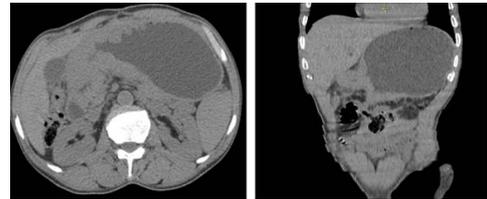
CT scan showing gastric carcinoma involving antrum and pylorus. A. axial, B. Coronal.
